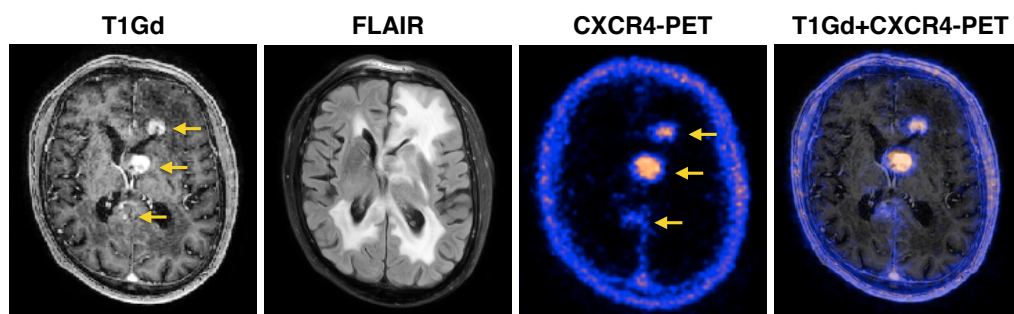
The multimodal scans of a patient with brain lymphoma. The CXCR4 directed PET identifies three lesions (marked by yellow arrows) with different level of progression. The smallest lesion is not yet visible on the T1Gd MRI scan, but it can be identified by PET enhancement.
